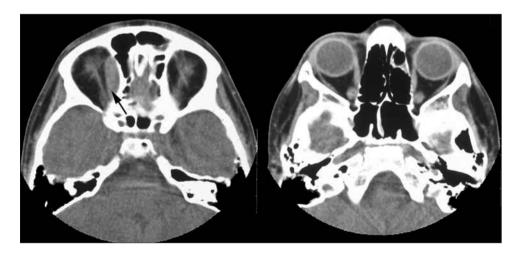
(Left) CT scan after a 6-month treatment shows a residual solid shrunk cyst (black arrow) located in the superomedial angle of the orbit. (Right) Proptosis has resolved.
